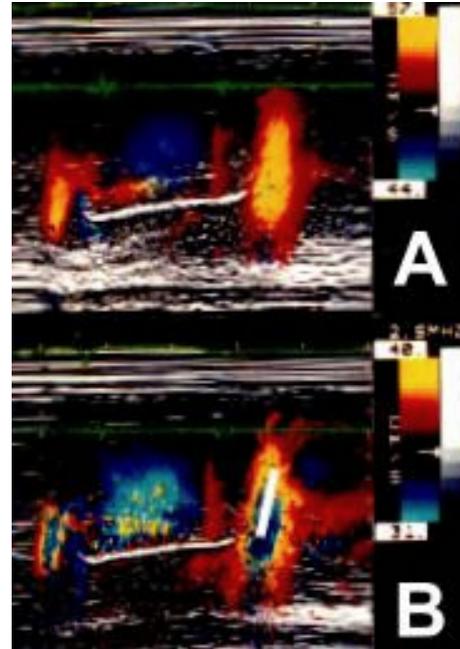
shows color M-mode echocardiographic variables for assessing left ventricular diastolic function. Panel A: The color M-mode Doppler echocardiograms of the left ventricular filling flow at a sweep speed of 100 mm/s. The ultrasound beam is interrogated from the left ventricular apex toward the center of mitral orifice as parallel to the filling flow as possible. The aliasing limit and baseline are adjusted to locate the center of minimized aliasing area around the mitral orifice in early diastole. Panel B: The first aliasing limit is changed to 70% of the maximal velocity in panel A. The aliasing boundary extends. The upward slope (black bar) is defined as the propagation rate of early diastolic filling flow.
